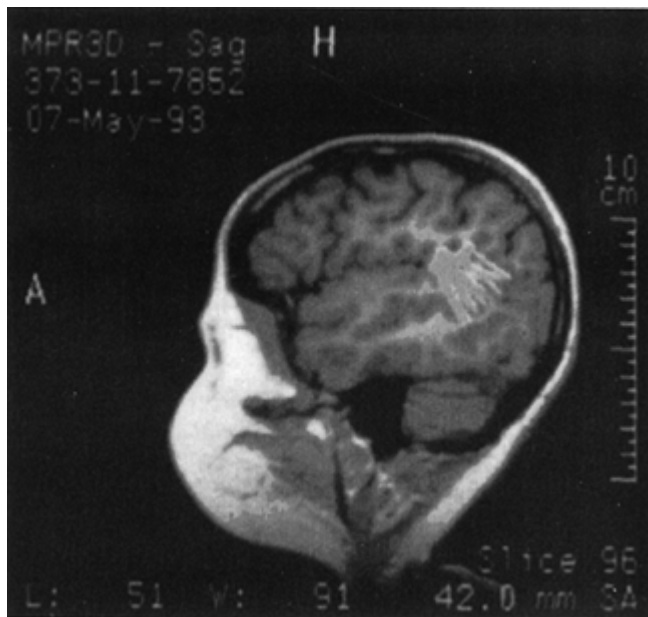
Magnetic resonance image (MRI) of another patient with Landau-Kleffner syndrome. In this example, the entire dipole, including its orientation, is displayed on the MRI. In (A) a sagittal section of the left sylvian region is shown. The dipolar orientation is perpendicular to the sylvian fissure and is angled in the anterior-posterior dimension, the suprasylvian projection being anterior to the intrasylvian one.
